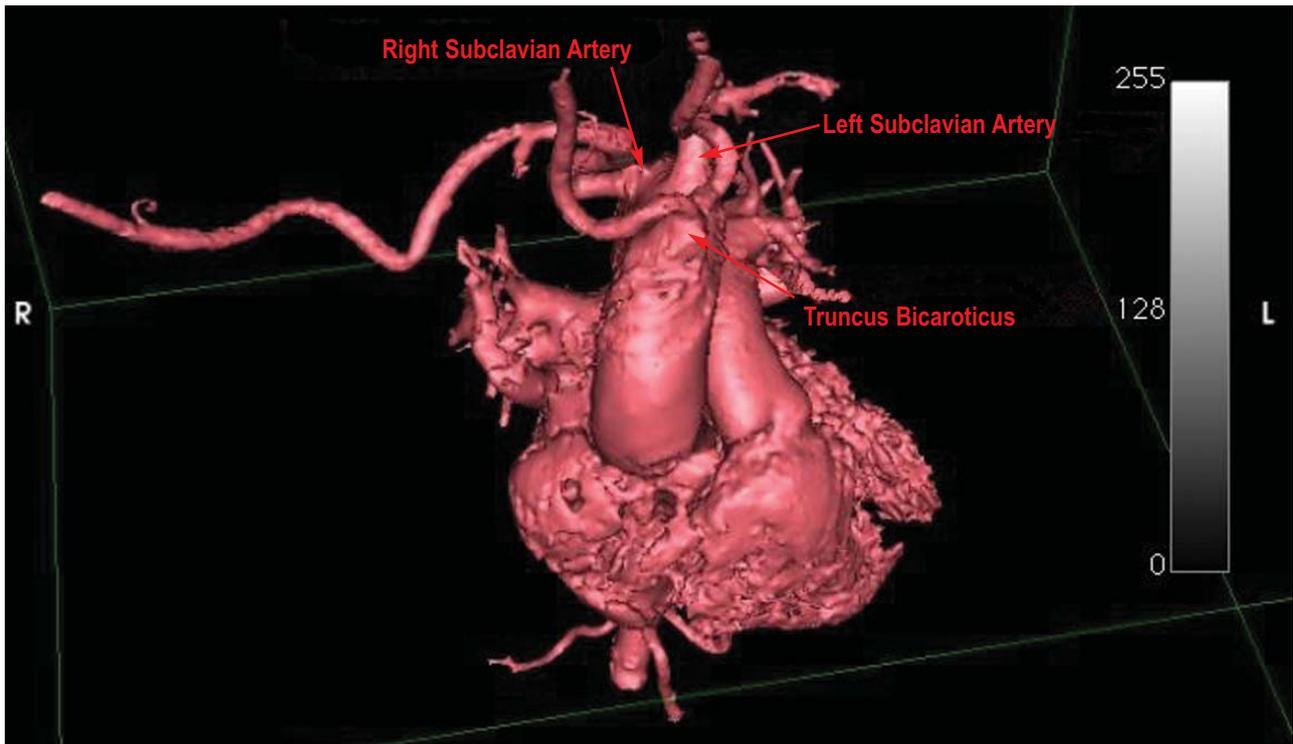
3D Chest CT reconstruction showing the supra-aortic branches from proximal to distal: truncus bicaroticus, left subclavian artery and the aberrant right subclavian artery.
